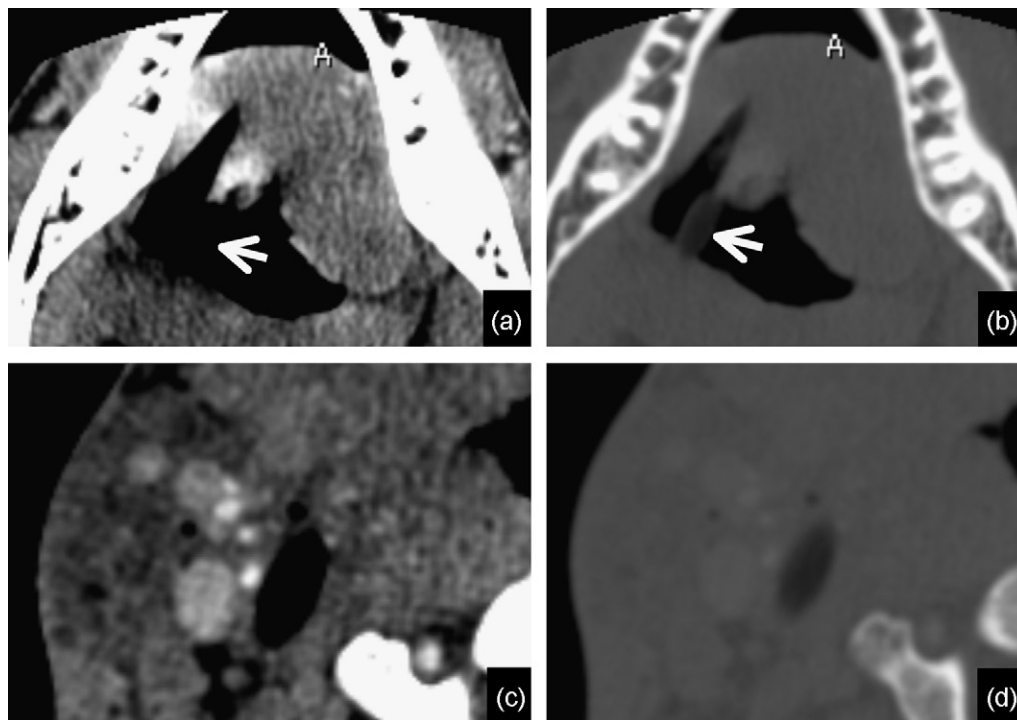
Comparison between enhanced CT with standard and higher CT window settings. With the standard CT window settings, the foreign body showed no attenuation and was indistinguishable from air (a). With higher CT window settings set to visualise the CT values of the foreign body, the foreign body was detected as a low-attenuation area (b). With the standard CT window settings, the non-attenuated area indicating the foreign body appeared to have some contact with the lumen of internal carotid artery (c), but separation was seen with the higher window settings (d), suggesting that the blood vessel walls were preserved.
